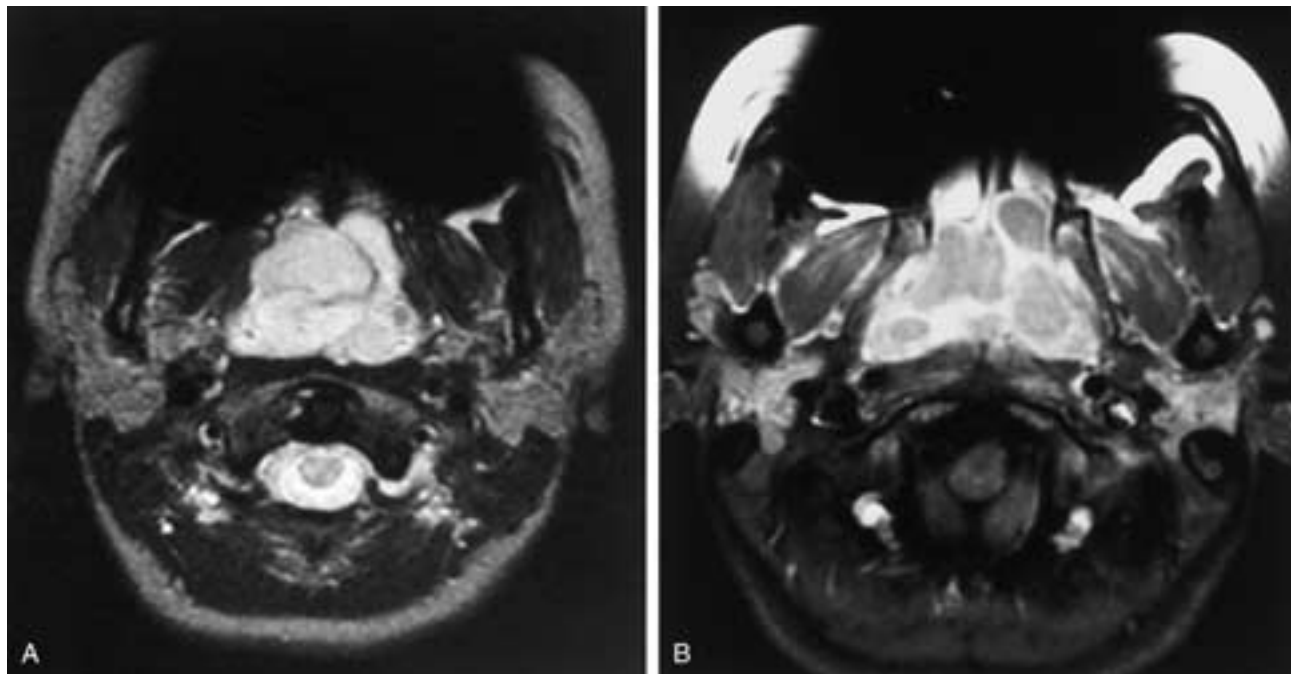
Non-Hodgkin's lymphoma involving the nasopharynx in 14-year-old female with nasal stuffiness and bilateral conductive hearing loss. A, Axial T2-weighted MR sequence. A bulky mucosal mass of increased signal intensity is seen filling the nasopharyngeal lumen. Note that there is no deep invasion of soft-tissue structures. B, T1-weighted MR sequence following gadolinium-DTPA. Peripheral enhancement is noted within the mass. There is a homogeneous appearance to the mass without evidence of necrosis. Diagnosis is non-Hodgkin's lymphoma.
